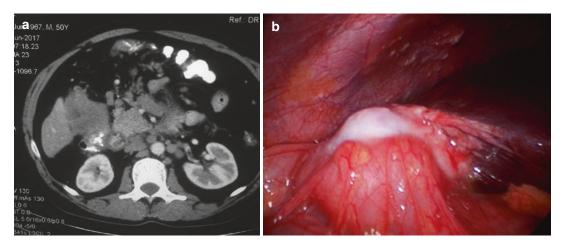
(a) Transverse colon and hepatic flexure lie very close to the gall bladder; CT showing gall bladder cancer infiltrating the hepatic flexure of the colon. (b) Gall bladder cancer infiltrating the colon
